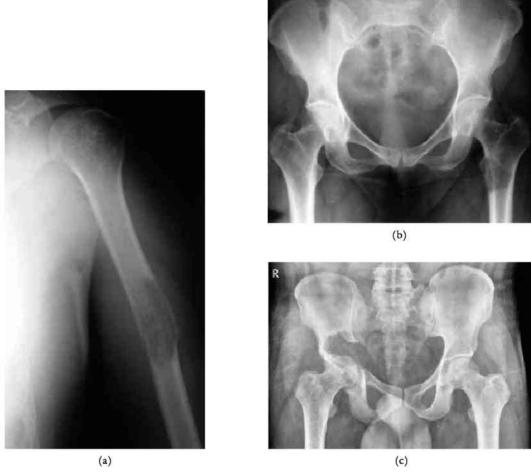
(a) X-ray of arm anteroposterior view showing metastasis from renal carcinoma, with pathological fracture. (b) X-ray of pelvis with both hips showing breast metastasis in the left proximal femur. (c) X-ray of pelvis with both hips showing thyroid metastasis in the right ilium and acetabulum with protrusio acetabuli.
